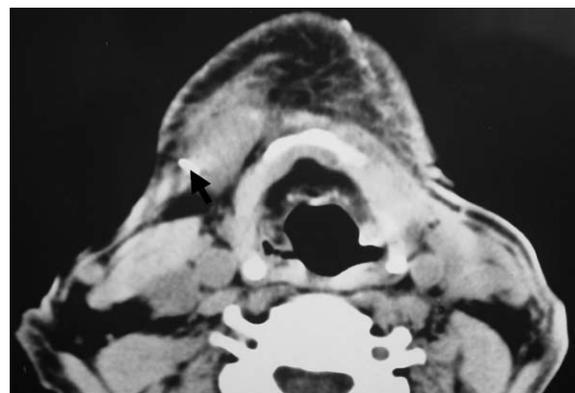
CT image after submandibular gland transfer. Note the high-density image in the posterior border of the gland.
